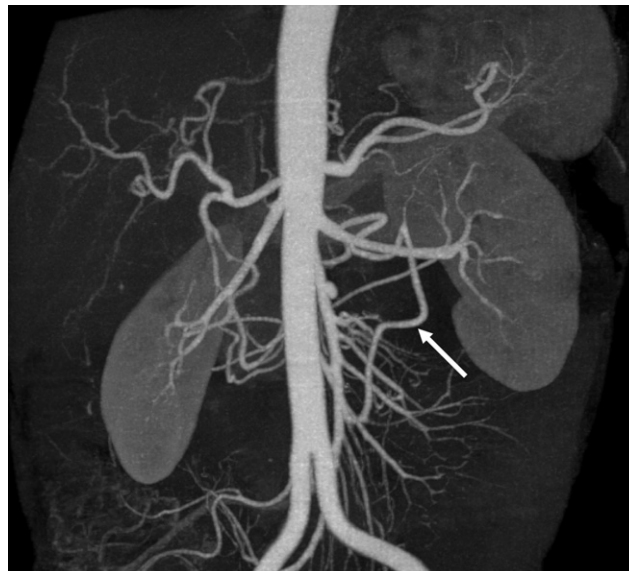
A 46-year-old woman, preoperative CTA study for potential liver donor. Scans were acquired with 64-slice MDCT at 100 kV and 120 mA. Coronal 3D MIP reconstruction demonstrates normal anatomic pattern of the splanchnic and mesenteric arteries. The arch of Riolan connecting the inferior mesenteric artery and middle colic branch of the SMA is also visualized (arrow).
